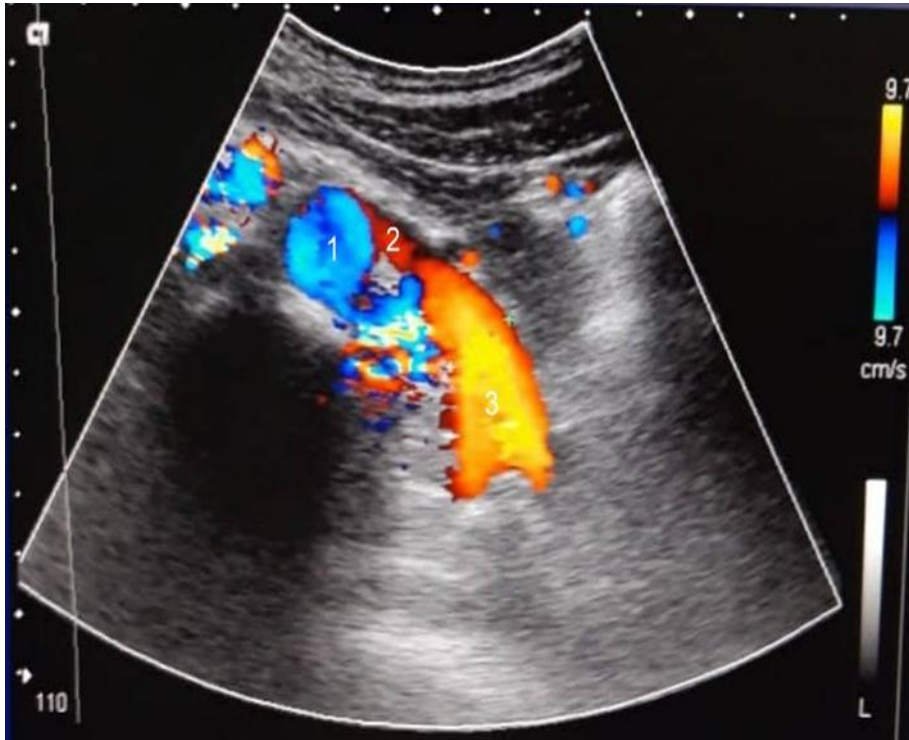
Ultrasound pattern of “the nutcracker syndrome” (1 – aorta, 2 – stenosed part of LRV, 3 – dilated part of LRV).
